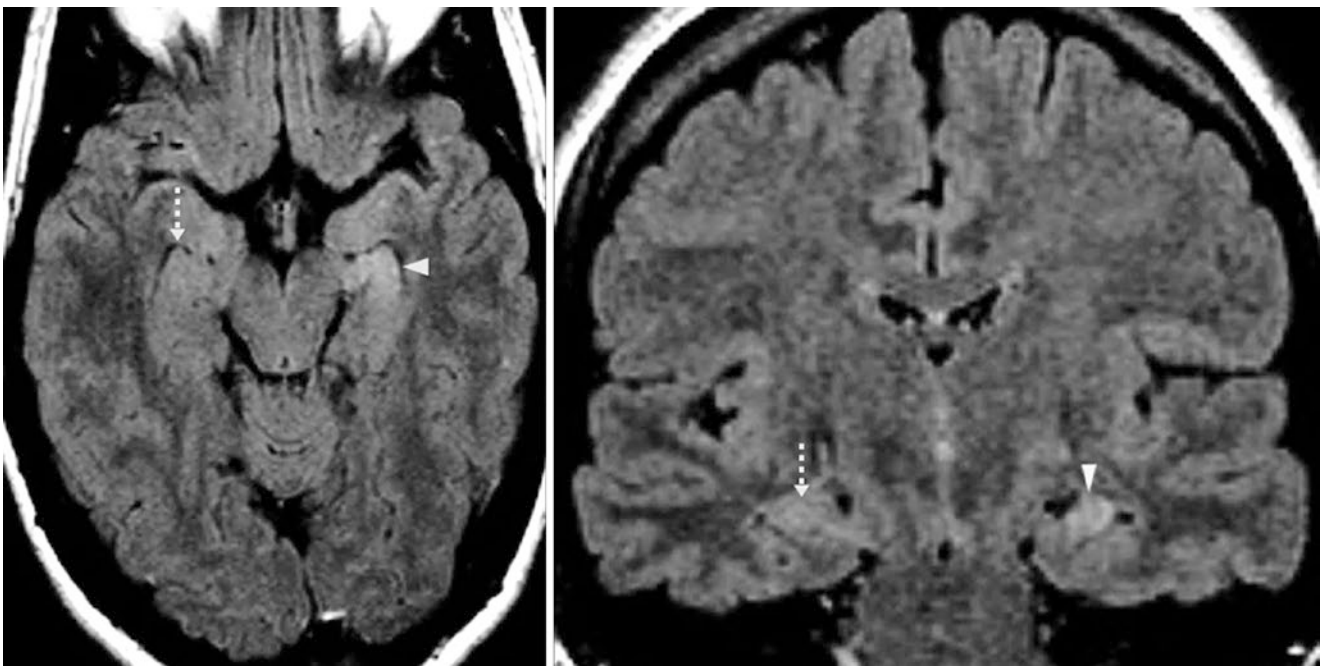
Comparison case of mesial temporal sclerosis. A 35-year-old with seizures underwent a 1.5 T MRI that showed subtle hyperintensity and mild atrophy of the left hippocampus (*arrowheads*) on axial
